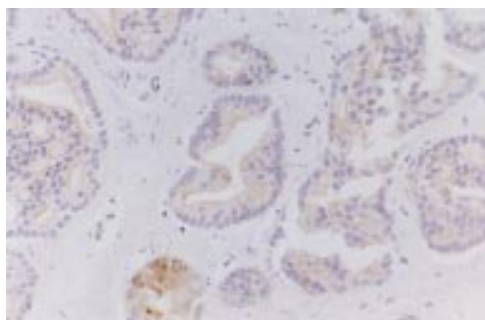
Weak expression of pancytokeratin in histomorphologically unaffected malignant epithelium within the high intensity focused ultrasound lesion. AE1/AE3 antibody.
